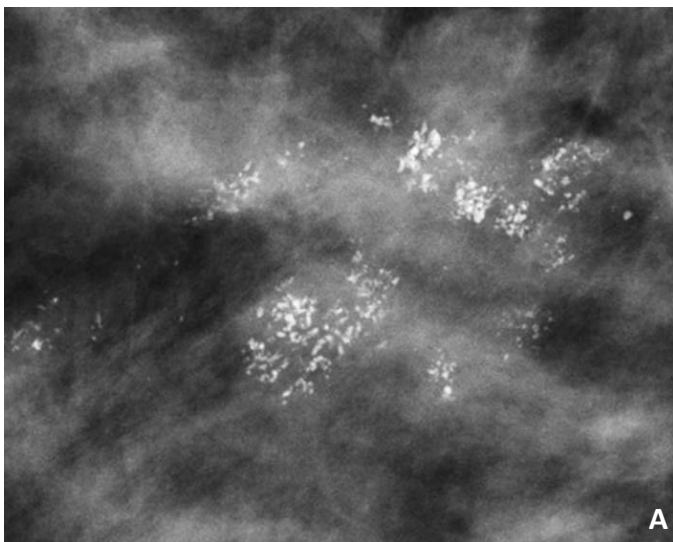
Ectopic Casting type calcifications. (A) shows casting calcifications in a segmental distribution, correspond to extensive high-grade DCIS. (B) MRI reveals corresponding clumped segmental non-mass-like enhancement (white arrows) in the right breast in association with a circumscribed 2 cm invasive malignancy posteriorly (black arrowheads), which was mammographically occult. This patient presented with bloody nipple discharge, corresponding to the linear ductal fluid signal (white arrowhead). A benign fibroadenoma was visualized in the medial right breast (open black arrow).
